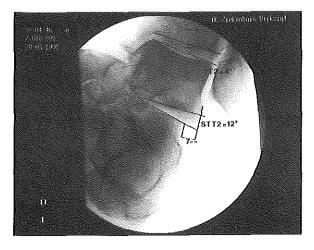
In this radiograph taken after actual stress has been applied (step 2), a small degree of talar tilt and increase of subtalar tilt can be seen.
